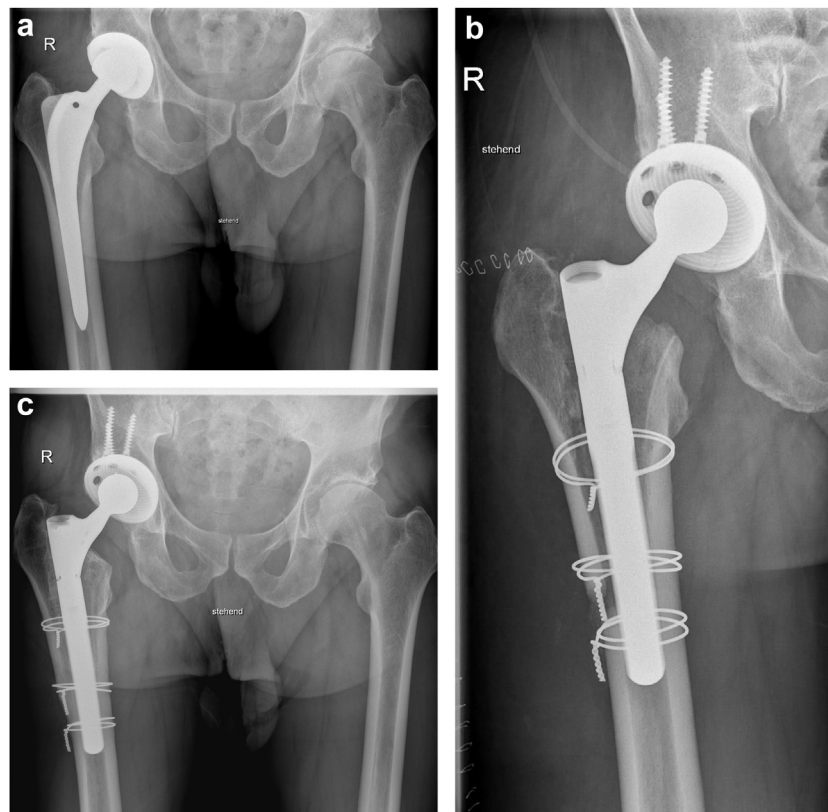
(a) A 73-year-old man with infected well-osteointegrated cementless hip arthroplasty on the right side. (b) Postoperative radiograph after transfemoral reimplantation of a modular revision stem Revitan curved and a press-fit cup (Allofit S; ZimmerBiomet, Winterthur, Switzerland) 6 weeks after transfemoral removal of the infected implants and temporary spacer placement. (c) Radiograph done 2.5 years postoperatively showing a complete osteointegration of the implants and healing of the approach and osteotomy.
